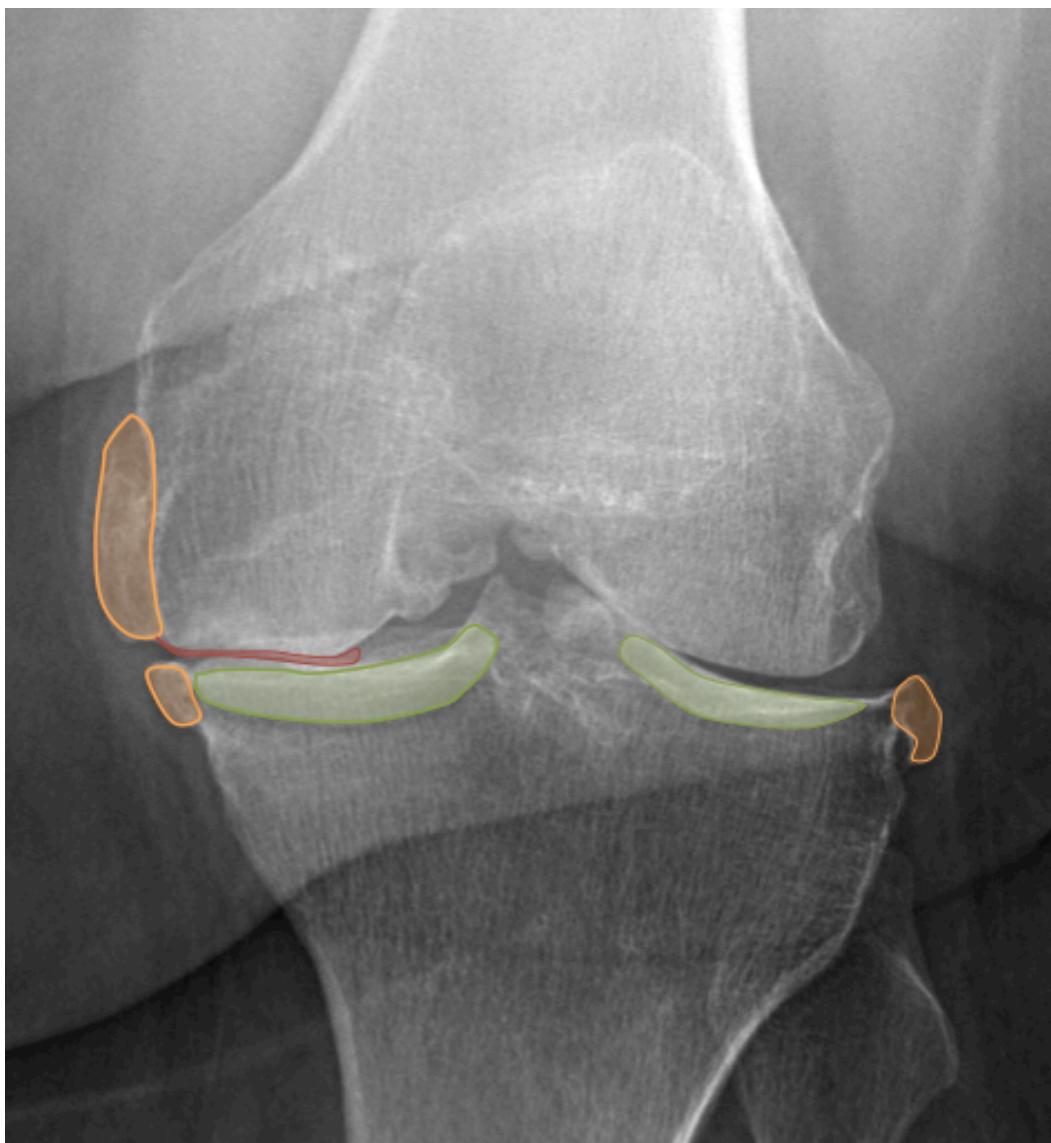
Radiograph of left knee with osteoarthritis signs:
